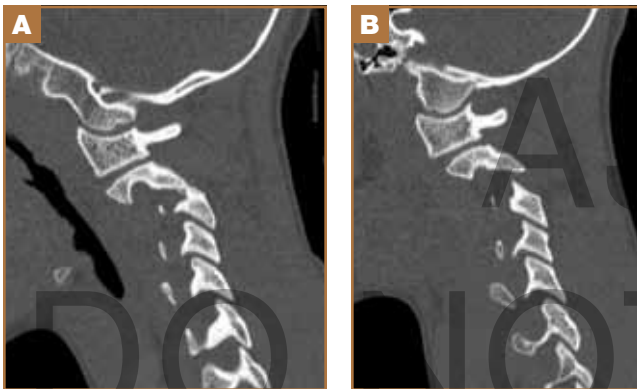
(A) CT scan of cervical spine shows left-sided jumped facet of C2-C3. (B) CT scan of cervical spine shows right-sided perched facet of C2-C3.
